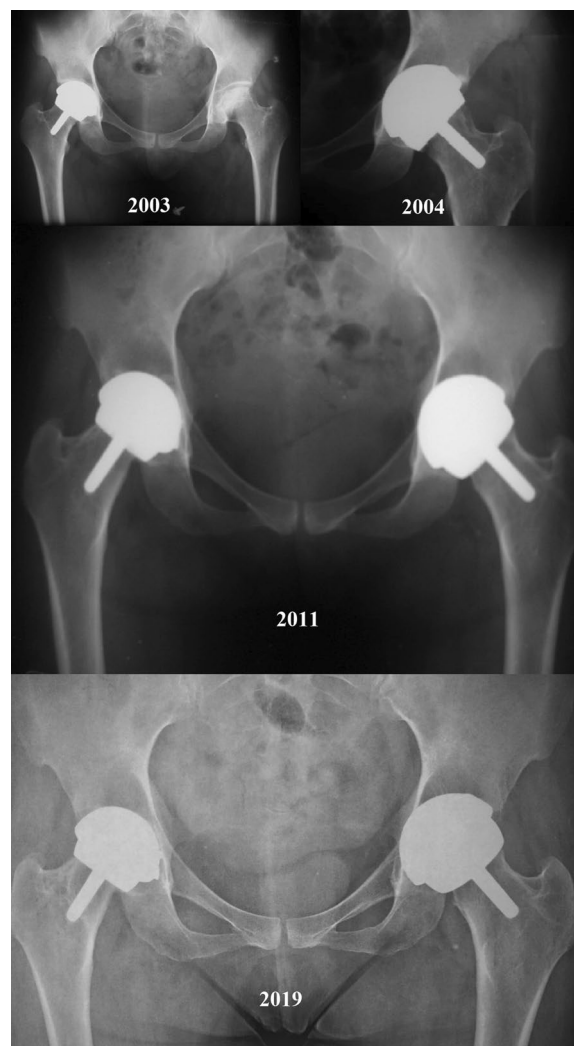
Plain radiographs showing the patient's follow-ups since she had her hips replaced till she started complaining of right hip pain in 2019
